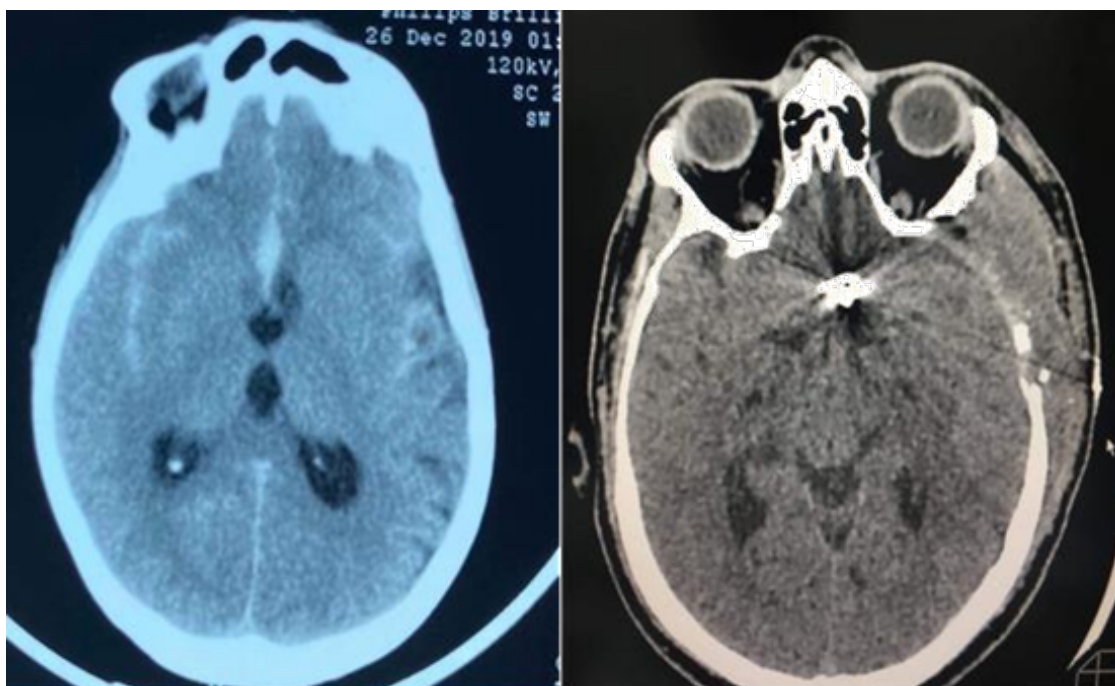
Non Contrast Axial Brain CT Scan with Diffuse SAH and Clip Application.
